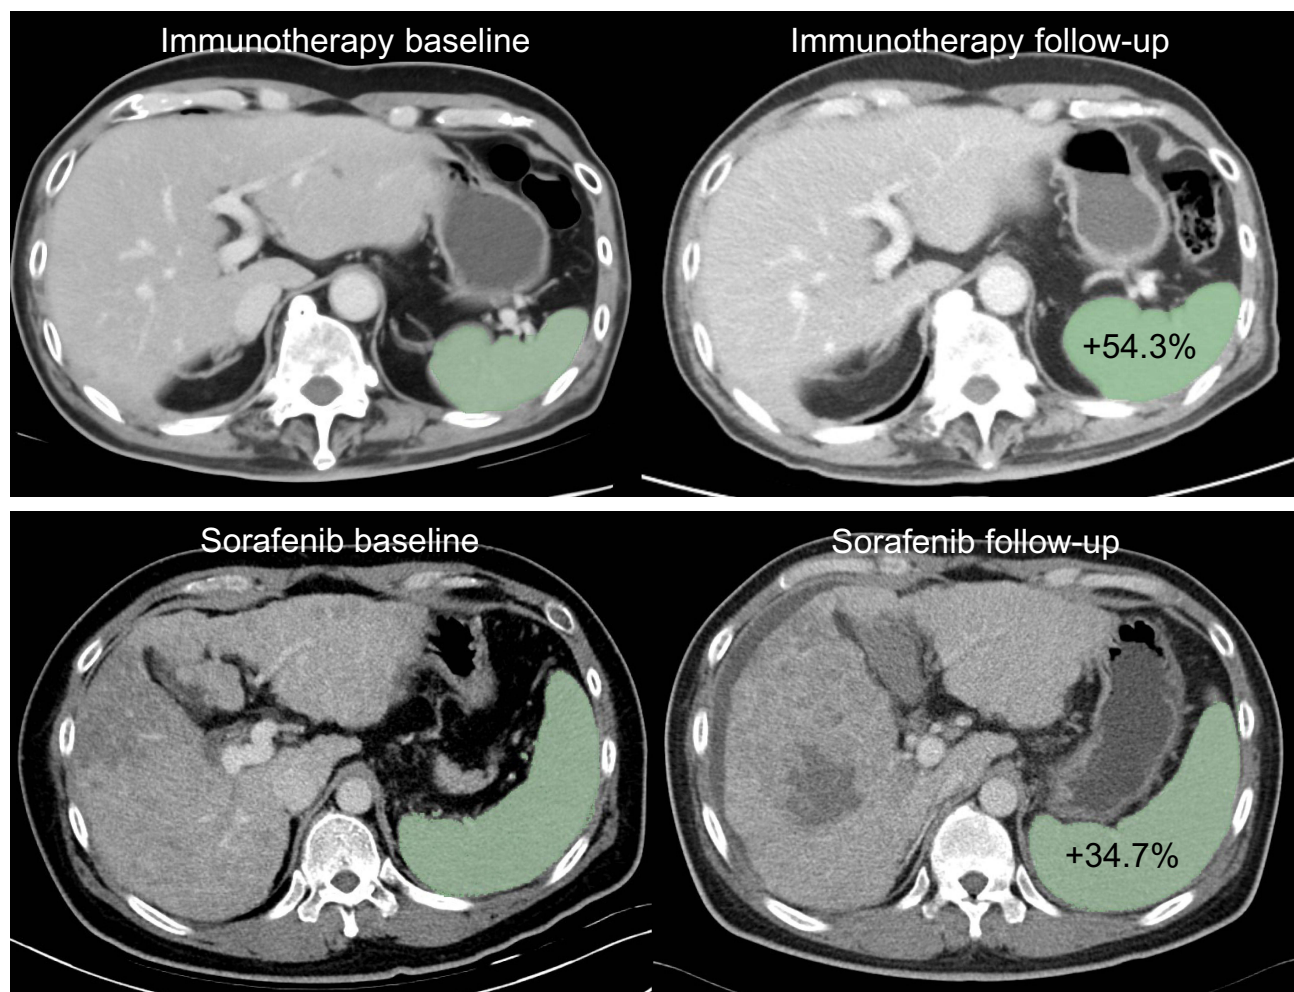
CT-based SV measurement. Upper panel displays the CT scans of a 66-year-old man who underwent therapy with atezolizumab, bevacizumab, and tocilizumab. His SV increased by approximately 54.3%, from 85 cm³ at baseline to 132 cm³ at his 41-day follow-up CT scan. His condition remained stable, and he experienced a DCB, with PFS of 13.8 months. Lower panel displays the CT scans of a 39-year-old man with advanced HCC treated with sorafenib. His SV increased by approximately 34.7%, from 656 cm³ at baseline to 884 cm³ at his 42-day follow-up CT scan. Despite treatment, his condition worsened, and he exhibited PFS of 1.4 months.
